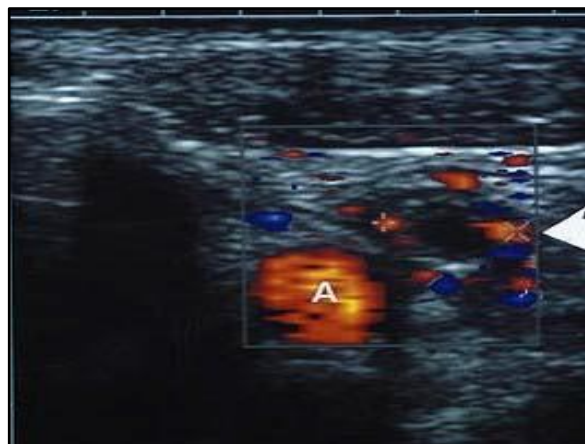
Transverse color – flow ultrasound of the RLQ of the abdomen demonstrates increased vascularity (arrow) in a fluid-filled structure corresponding to acute appendicitis. External iliac artery [A] is identified.
